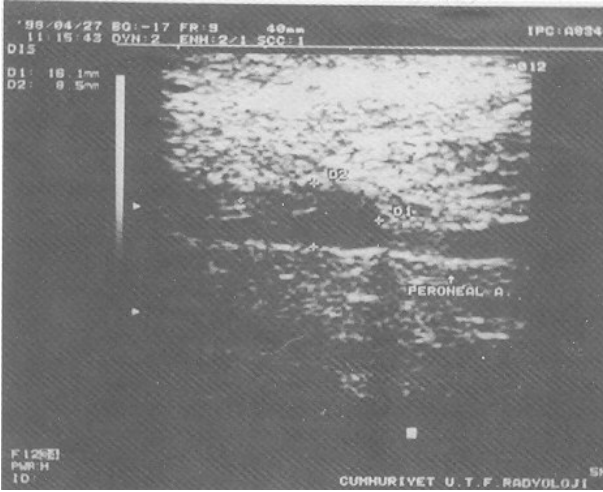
Ultrasonographic appearance of peroneal artery aneurysm.
